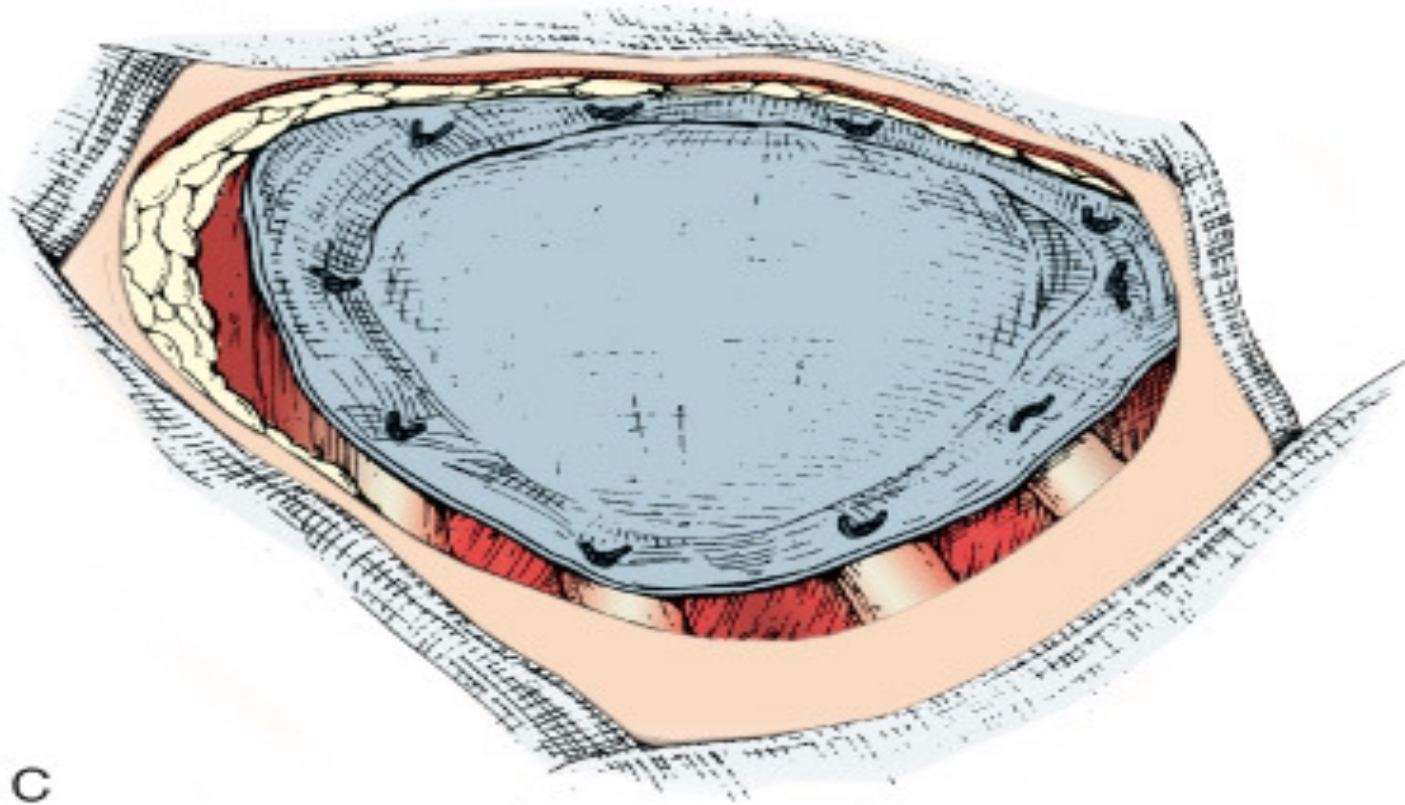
Chest wall reconstruction. A, Radiograph of a resected chest wall tumor. B, Spreading methylmethacrylate over mesh. C, Prosthesis sutured in place. D, Omentum sutured over prosthesis. E, Myocutaneous flap sutured to skin.
